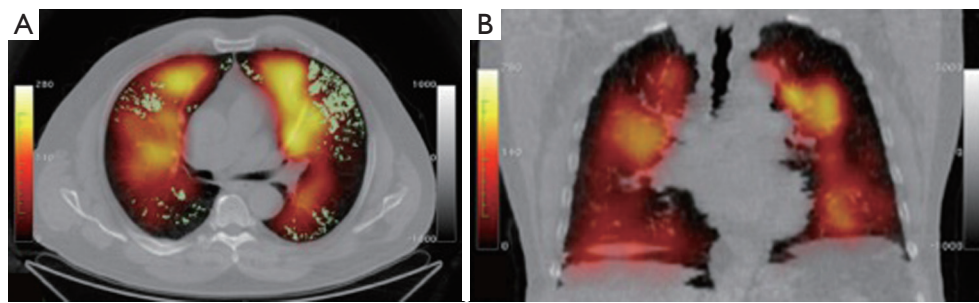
Technegas ventilation SPECT/CT fusion images of a 68-year-old man with moderately severe COPD. (A) Axial dimension, with well-ventilated areas (bright yellow), less ventilated areas (red) and non-ventilated areas (black). Green indicates emphysema determined by a CT density mask, with pixel density less than -910 HU. Note that poorly ventilated areas tend to correspond to areas of emphysema. Some non-ventilated areas are not associated with emphysema, suggesting airway obstruction without macroscopic parenchymal destruction in these areas; (B) coronal reconstruction of ventilation map.
